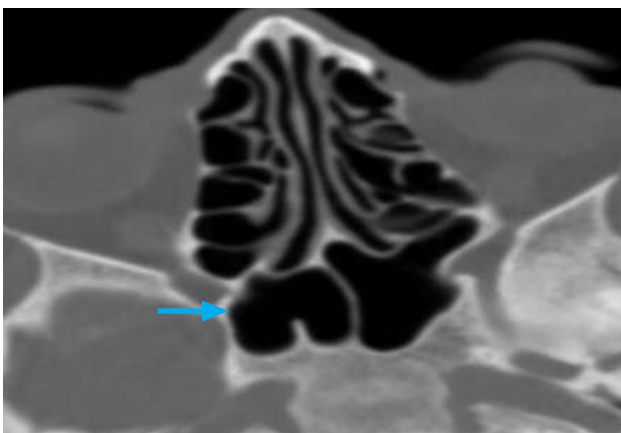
Axial view of CT PNS showing Onodi cells (posterior ethmoid air cells) superior to the sphenoid sinus is also noted.
